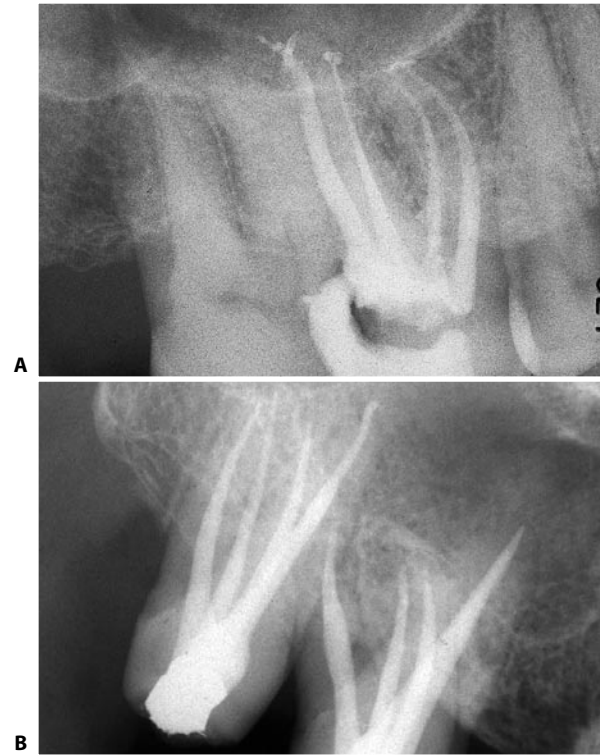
A. Postoperative radiograph of the upper right first molar with a mesiopalatal canal with an independent foramen. B. In this patient, both the upper right first and second molars reveal a mesiopalatal canal with an independent foramen.
